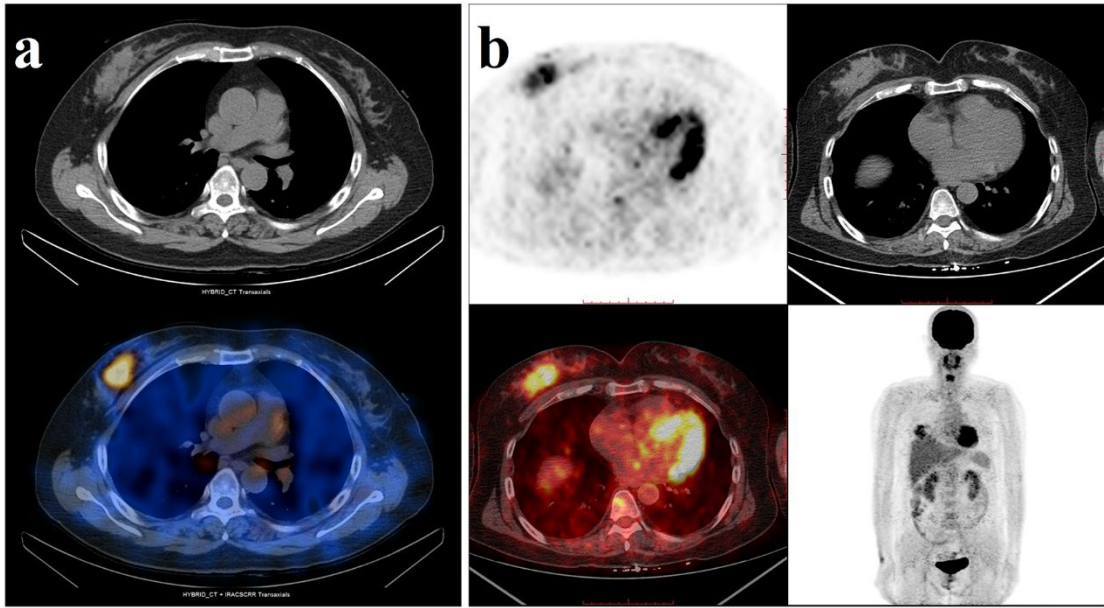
Images of Patient BR001 at 1 h after injection of ^{99m}Tc -NM-02 (a) and ^{18}F -FDG (b), respectively.
